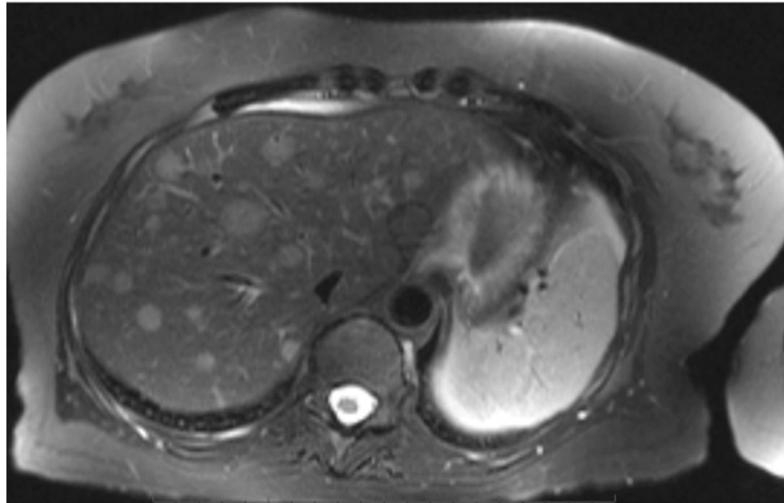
MRI demonstrating numerous enhancing hepatic metastases on a T2 weighted image.
